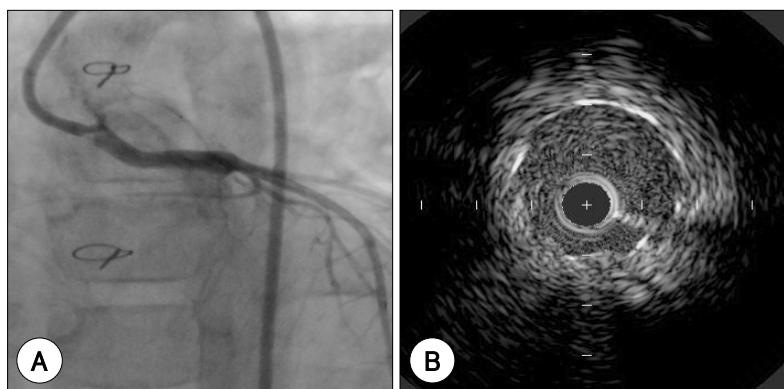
The coronary angiogram and intravascular ultrasound imaging following stent deployment. Excellent angiographic result (A). The stents are completely apposed against the vessel wall (B).
